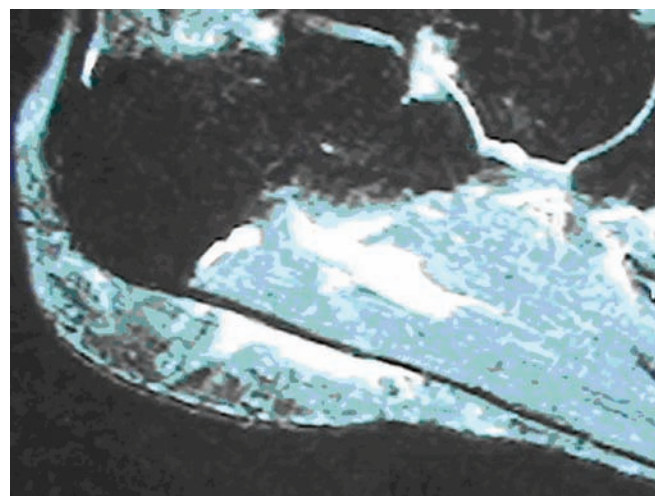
MRI of a fat-pad rupture in an elite triple jumper. Note the intact fascia and musculature, and disruption of the fat pad.
